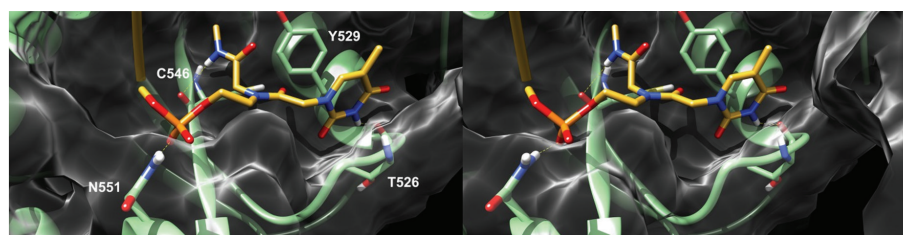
Stereoview of the predicted binding mode of the 5'-capped AS of siRNA 16 in the hAgo 2 X-ray structure. For clarity reasons, only the PNA structure is depicted (yellow sticks) while the RNA backbone is shown as an orange transparent ribbon. The protein is depicted as green sticks (interacting residues) and ribbons and white transparent surface. H-bonds are indicated as yellow dashed lined.
